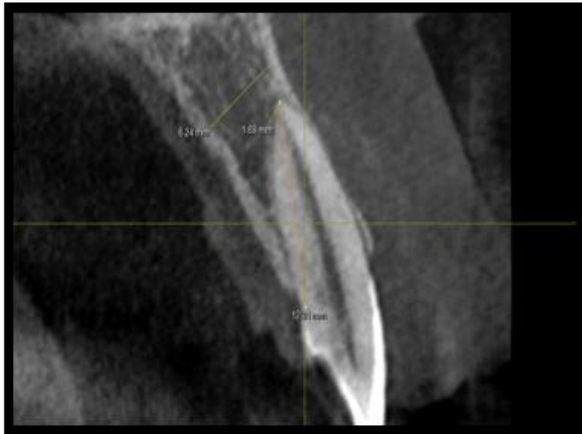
Pre-operative CBCT and IOPAR
